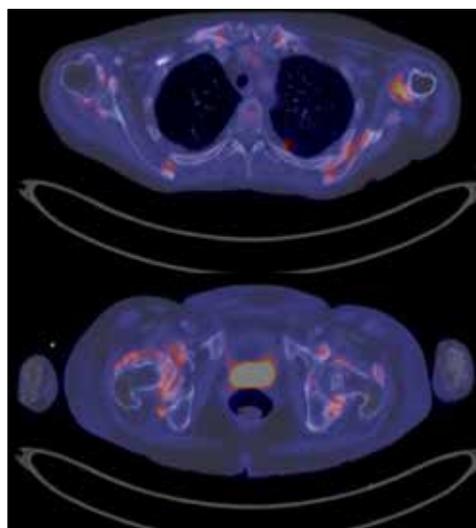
Positron emission tomography with fluorodeoxy-glucose computed tomography (FDG-PET/CT) performed 9 months after starting voriconazole showing bone changes in the shoulder and pelvic girdles.
